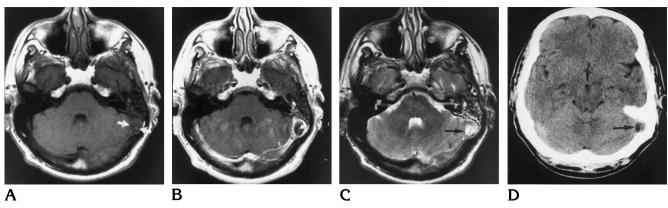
A, T1-weighted (650/11/1) MR image shows hypointense nodule in left transverse/ sigmoid sinus junction (*arrows*).
